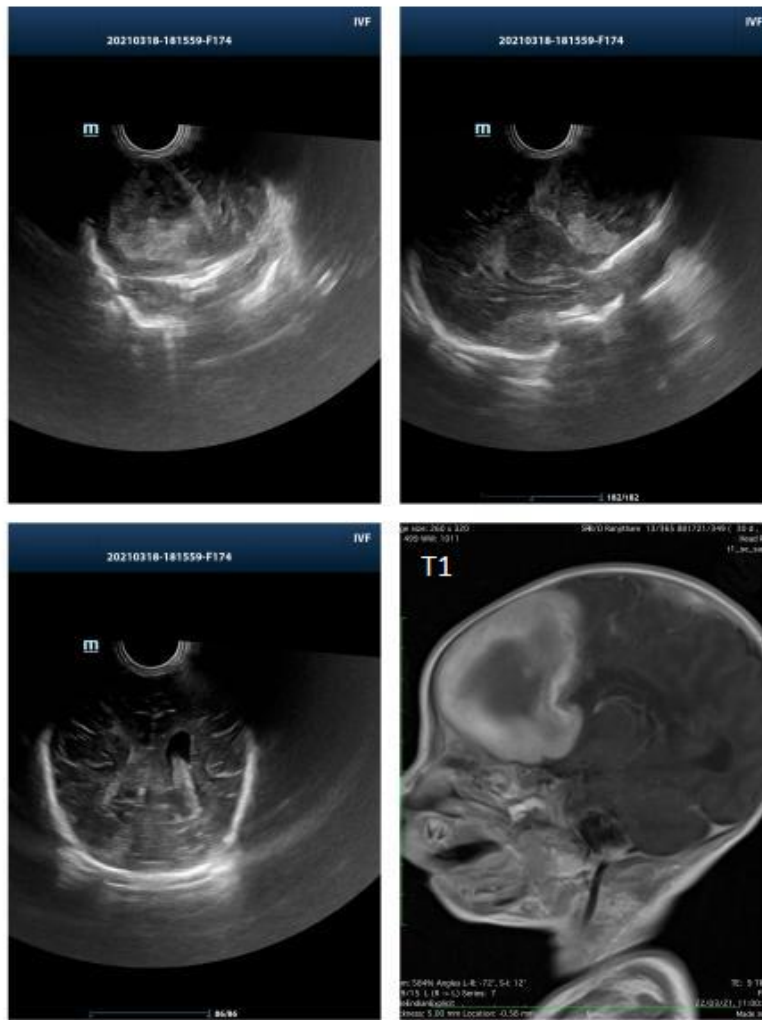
Neurosonogram and MRI depicting acute intraparenchymal haemorrhage with intraventricular extension on the right and subdural haemorrhage in the right frontoparietal lobe
